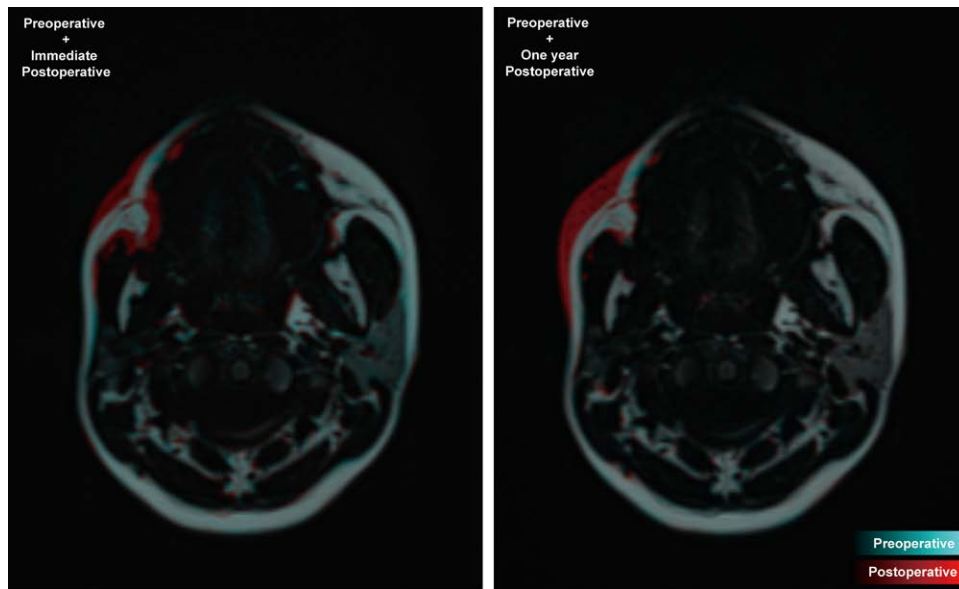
Fused MRI scans (patient 16, lower face) show restoration of fat at different levels after AFT using the AFFR principle. In addition, the overall postoperative contour was close to normal (fat images in 3-dimensional Dixon sequence: preoperative, cyan; postoperative, red).
